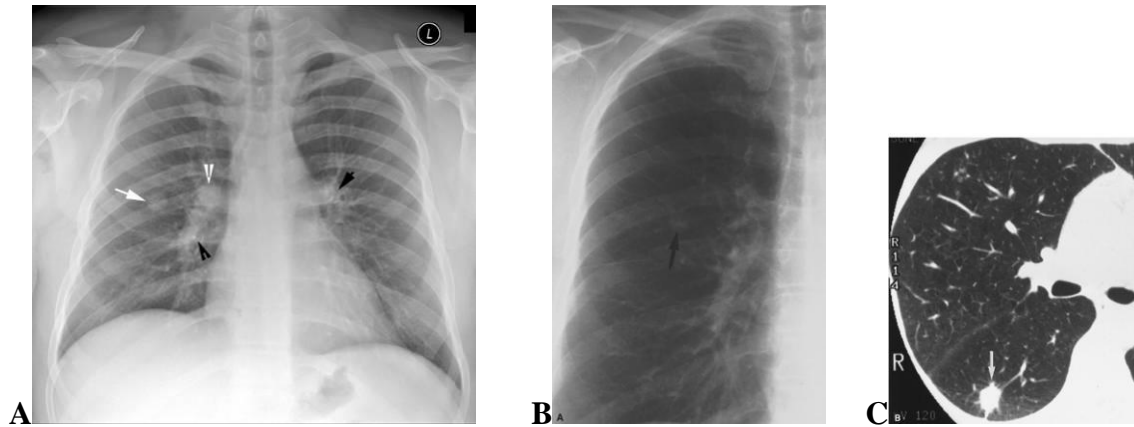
Adenocarcinoma right lung. (A) Frontal chest radiograph. Note the solitary pulmonary nodule. White arrow points to the solitary pulmonary nodule. White arrowhead points to the right hilum which is full and dense. Black arrowheads point to calcification, evident in both hilum. Adenocarcinoma presenting as solitary pulmonary nodule. (B) Cone-down view of posteroanterior radiograph shows nodule in the right mid-lung (arrow). (C) Thin-section CT shows 12-mm nodule with spiculated margins (arrow) in the superior segment of the right lower lobe
